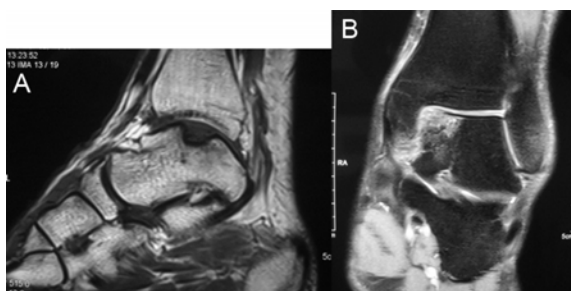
The MRI at 1 year of follow-up revealed minimal bone edema surrounding the subchondral bone defect at the medial talar dome.
